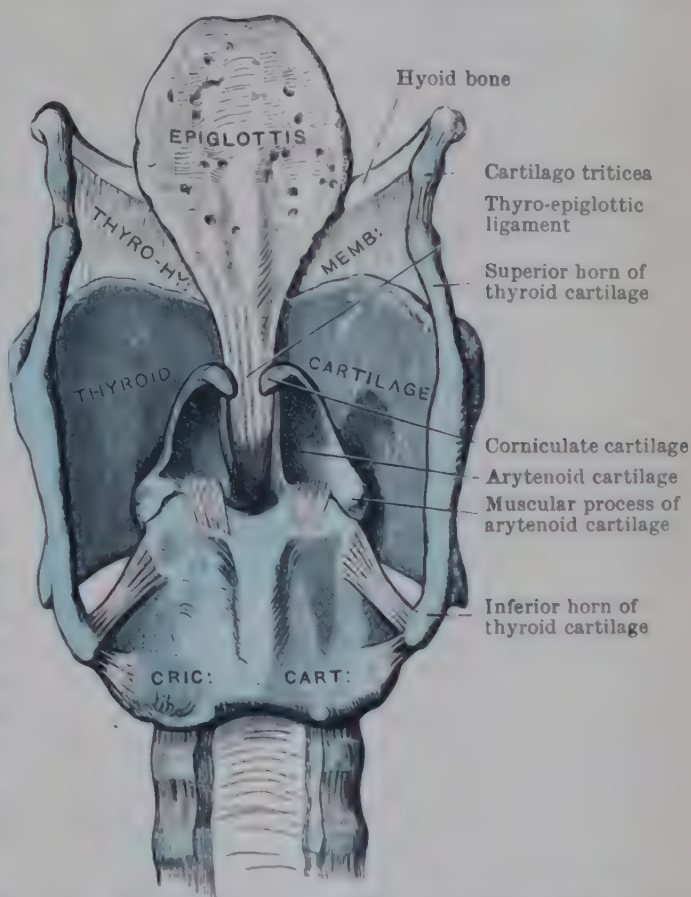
POSTERIOR ASPECT OF CARTILAGES AND LIGAMENTS OF LARYNX.
